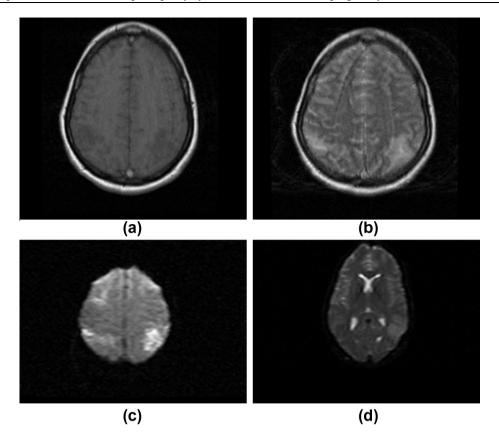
(a) T1 WI showing bilateral and symmetrical occiopitoparietal low SI. (b) T2 WI showing bilateral and symmetrical occiopitoparietal high SI. (c and d) DWI and ADC map showing free diffusion with high SI in DWI due to T2 shine through and high SI in ADC map denoting vasogenic edema follow up after 2 weeks revealed complete resolution.
